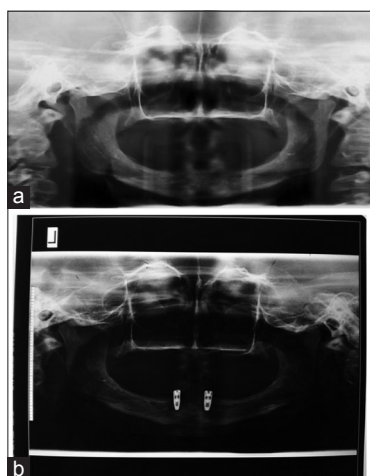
Panoramic radiographs of Case 2. (a) Preoperative, (b) with implants
